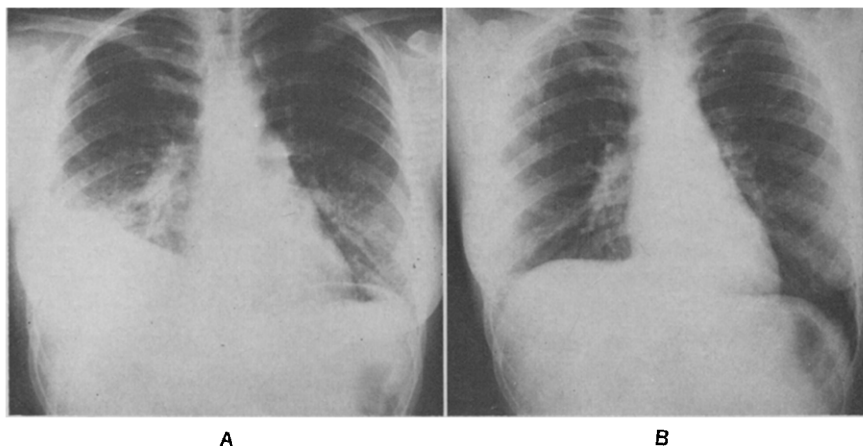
Chest x-ray changes in patient O.R. before (A) and after (B) treatment of right lobe hepatic abscess. Elevated right diaphragm, right lower lobe atelectasis, and pleural effusion present preoperatively have markedly improved early postoperatively.
